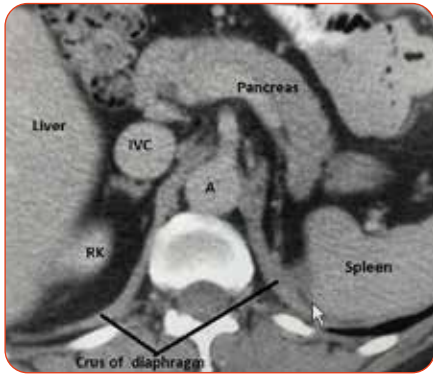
Enhanced axial CT scan showing the position of the spleen and pancreas following a left nephrectomy. IVC = inferior vena cava. A = aorta. RK = right kidney which is just coming into view on this slice.
